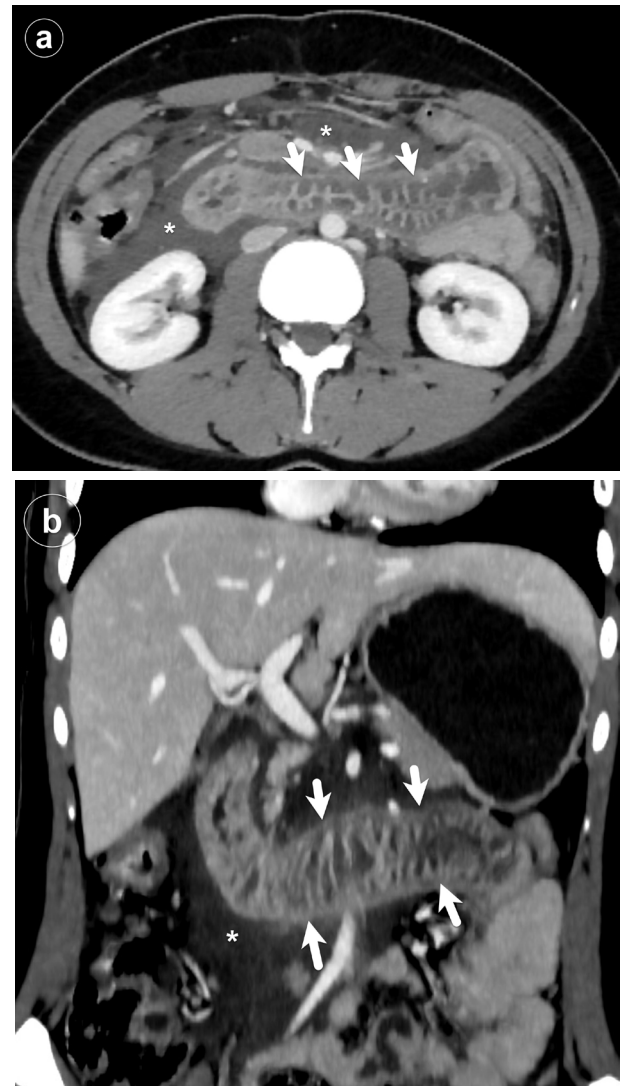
a) Axial and b) coronal abdominal CT images show mucosal hyperenhancement and severe submucosal edema of the duodenum consistent with a "bowel target sign" (arrows). Note the peri-intestinal free-fluid (*).
